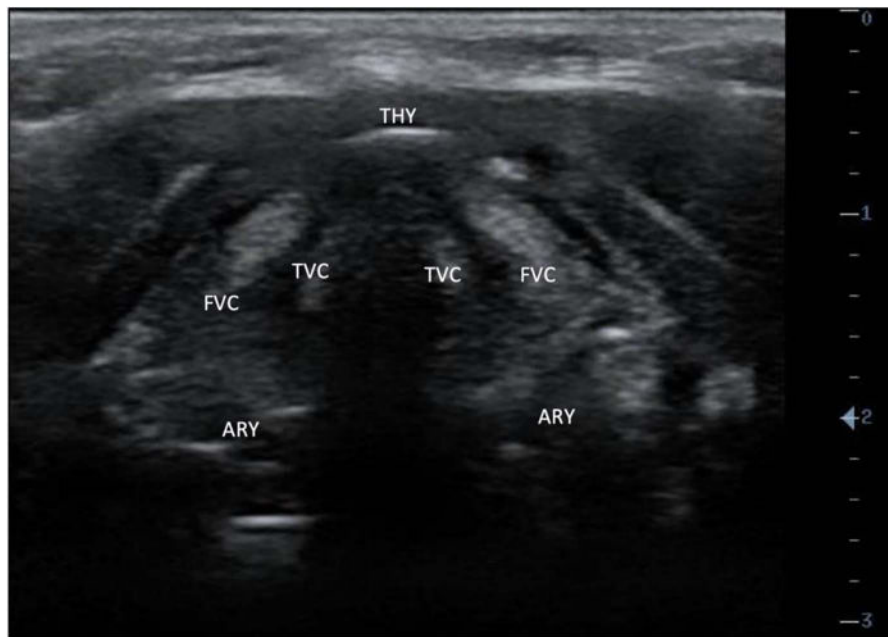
Ultrasound anatomy of the glottis in a transverse view. THY, thyroid cartilage; FVC, false vocal cords; TVC, true vocal cords; ARY, arytenoid cartilage (figure courtesy of Vinicius Quintao).
